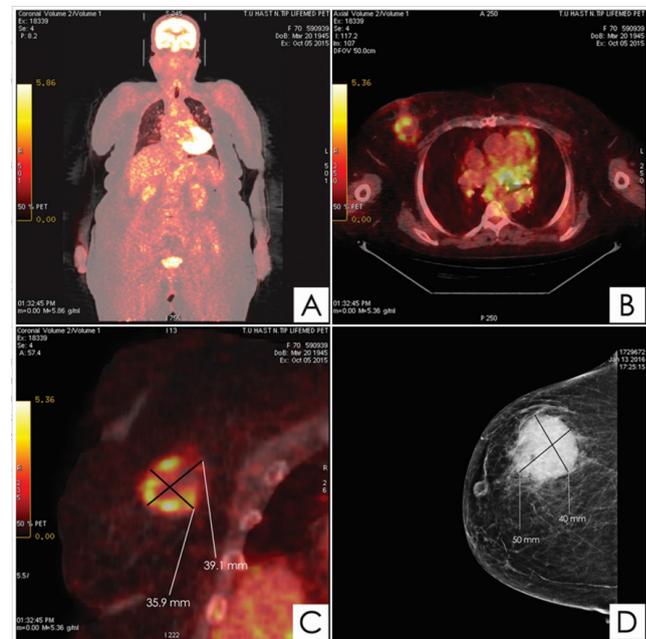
PET and mammography images of the patient A. Increased FDG uptake (involvement) assessed as lymph node metastasis B. and C. Increased FDG uptake (involvement) in the breast D. Mass appearance in mammography
